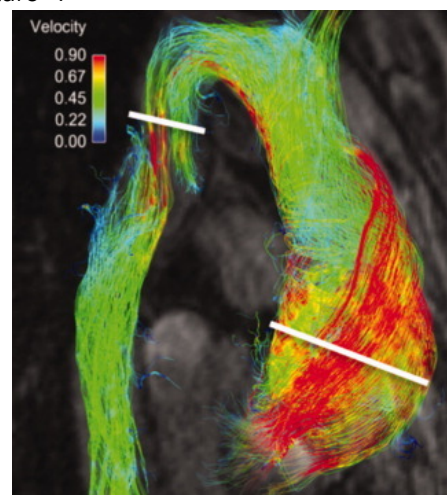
4D flow MRI LV<sup>94</sup>.
